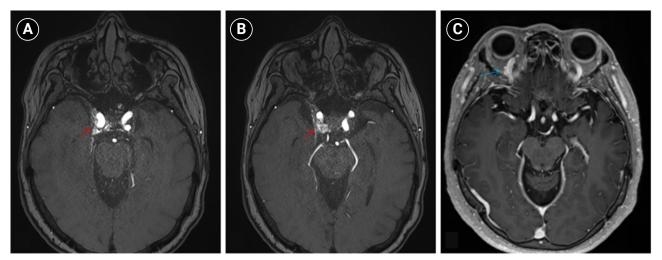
Brain magnetic resonance imaging (MRI) findings. (A, B) Non-contrast time-of-flight magnetic resonance angiography shows a high flow-related signal (red arrows) within the right cavernous sinus. (C) Contrast-enhanced T1-weighted MRI demonstrates asymmetric dilation of the superior ophthalmic veins (blue arrow), more prominent on the right.
